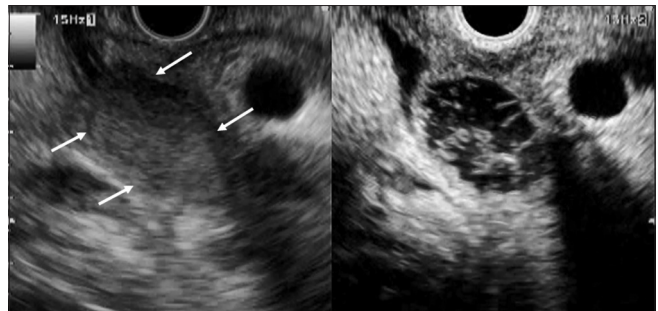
A case of metastatic lymph node from pancreatic cancer. Conventional endoscopic ultrasound (left image) shows low-echoic lymph node surrounding with common bile duct (arrows). Contrast-enhanced harmonic endoscopic ultrasound (right image) shows the lesion is enhanced heterogeneously that indicates a malignant lymph node. Therefore, endoscopic ultrasound fine-needle aspiration was performed in this lymph node for T-staging of pancreatic cancer before surgery
